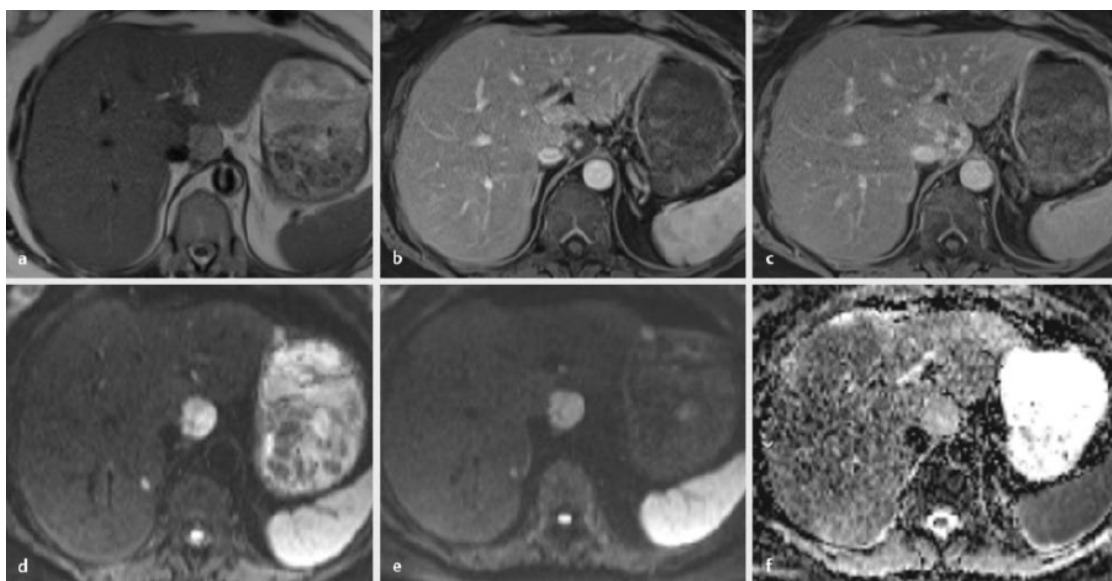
62-year-old female patient with breast carcinoma who was suspected of having a liver metastasis in S1 on staging CT. a: axial T2-HASTE sequence shows a clearly hyperintense lesion; b, c: in contrast dynamics, there is peripheral nodular centripetal enhancement, typical of a cavernous hemangioma; d: in DWI, the lesion is hyperintense at $b = 50 \text{ s/mm}^2$; e: hyperintense visualization of the lesion even at $b = 600 \text{ s/mm}^2$; f: however, the lesion also appears relatively hyperintense on the ADC parameter image; This is a typical finding of a “T2-shine-through” artifact.
